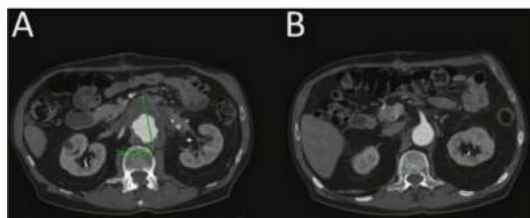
• CTA axial images depicting (A) a 7.4-cm paraanastomotic juxtarenal aortic aneurysm and (B) a healthy aortic segment in the region of the SMA.
